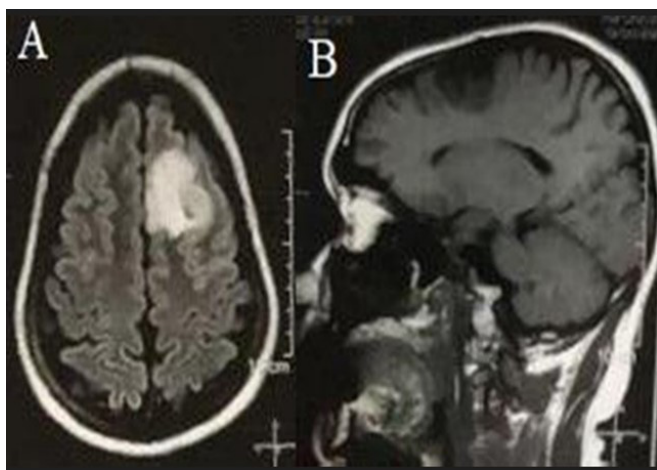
Magnetic resonance in axial section FLAIR (A) and sagittal T1-weighted (B) showing hyperintense image (A) and hypointense image (B) in the upper frontal gyrus of the left frontal lobe with characteristics of primary glial tumor
